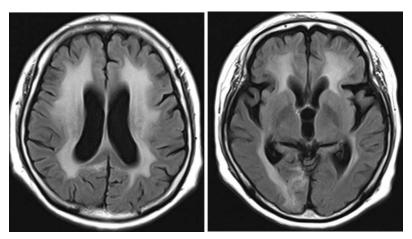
Axial MRI images of the brain show age-inappropriate frontal and parietal lobe severe atrophy in a young female patient with longstanding SLE.
